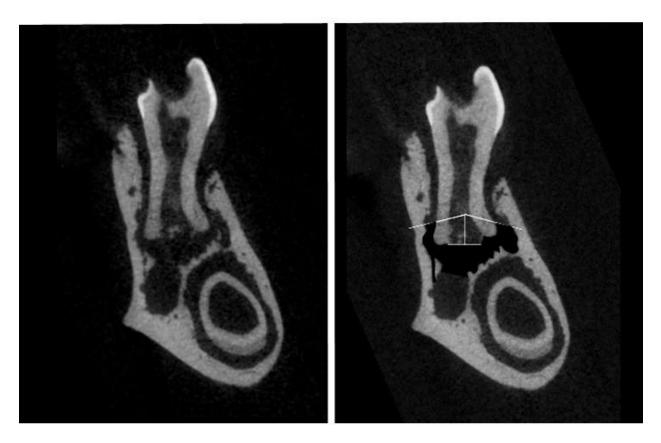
Estimulação da lesão periapical. Camundongo anestesiado e posicionado na mesa de retração mandibular; Seleção do primeiro molar inferior; Polpa do primeiro molar inferior exposta; Mandibula dissecada após 21 dias da exposição pulpar; Hemimandíbula; Microtomografia computadorizada destacando a abertura coronária suficiente e a formação da lesão periapical.
